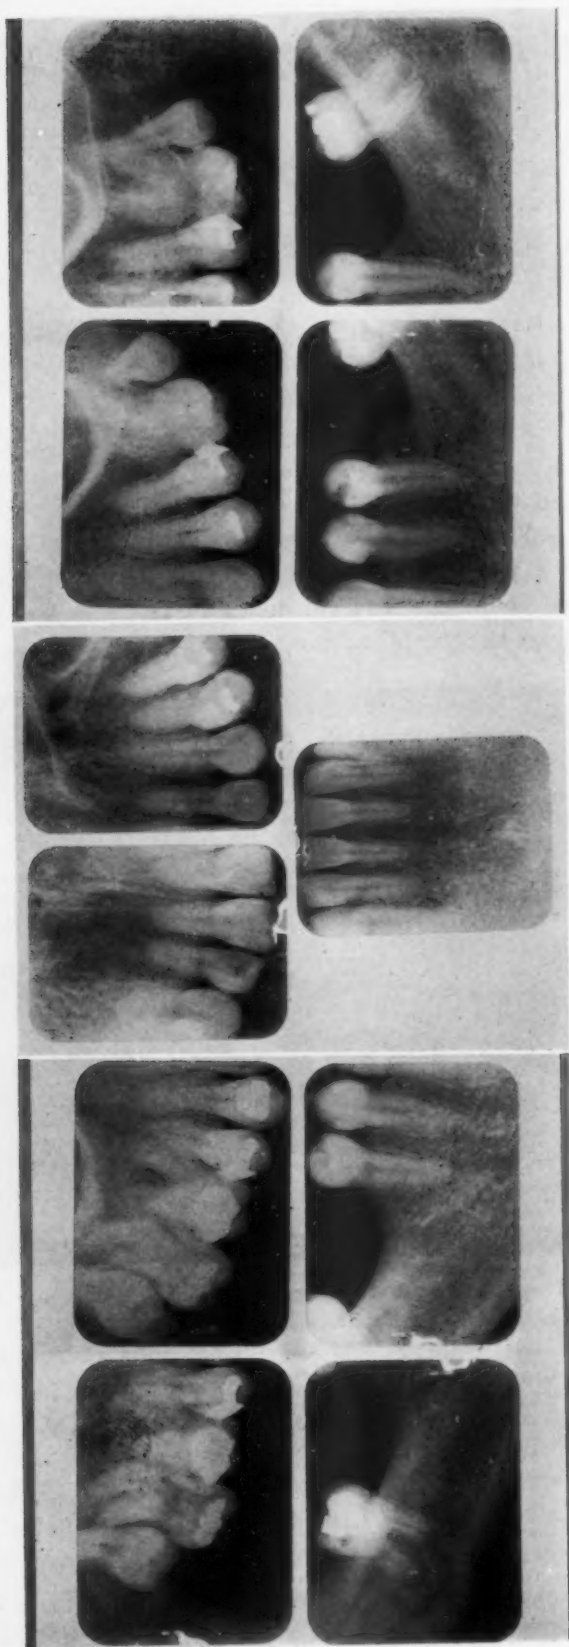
Roentgenograms of the dentition shown in Fig. 1. Note the root resorption of the incisor teeth.
